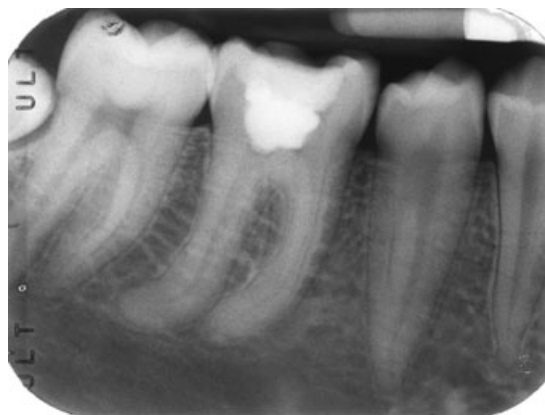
Preoperative radiograph showing tooth 46 with a distinct 80–85° apical curvature in the distal root. There is a slight widening of the lamina dura/periodontal ligament space associated with both roots.
